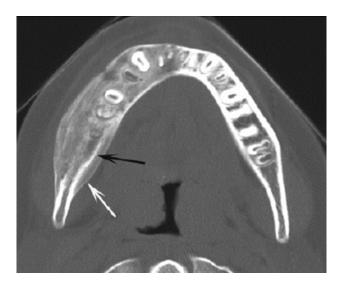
Axial CT image reveals periosteal new bone (white arrow) and evidence of the original cortex (black arrow). Note the increased width of the mandible.
